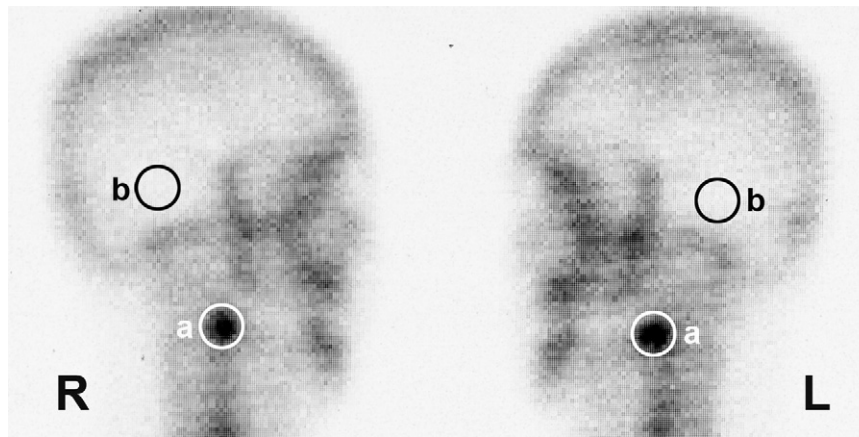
Regions of interest drawn on the scintigram to indicate the extraction socket region (a) and the temporal bone of calvarium (b). R, right side, PRF-treated site; L, left side, non-PRF-treated site.
